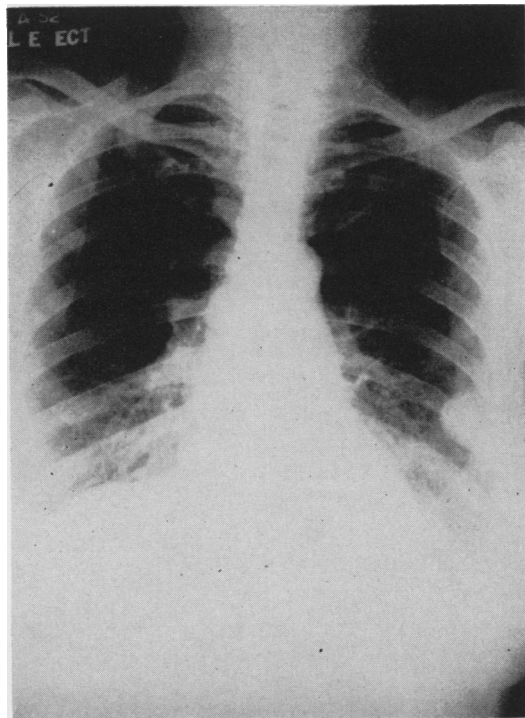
Roentgenogram of the chest showing a circumscribed neoplasm in the region of the left eighth posterolateral rib. Same case as Figure 7.
